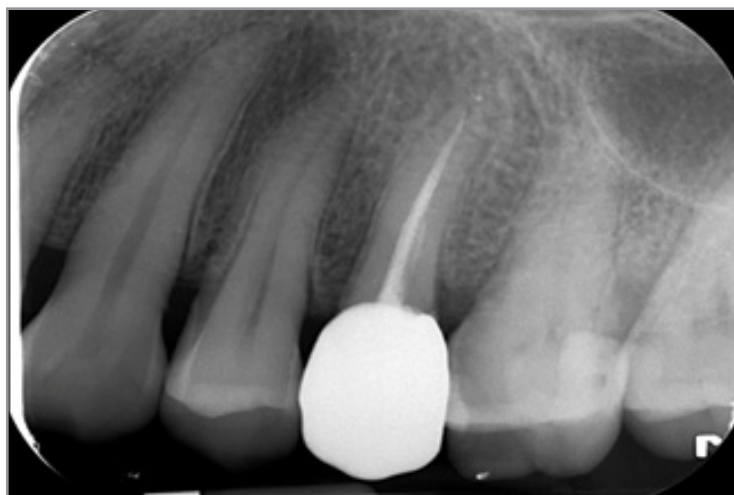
PA Xray after prosthetic restoration
